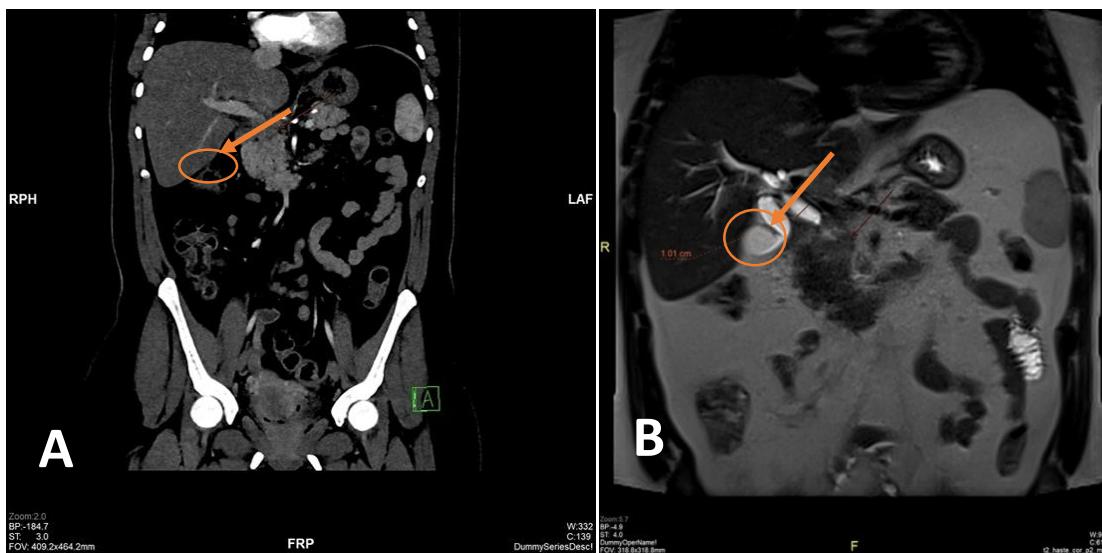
A) CT scan of the abdomen showing the ill-defined lesion and dilated CBD. B) MRCP of the abdomen showing ill-defined mass at the mid aspect of the CBD inseparable from the pancreatic head (arrows), resulting in biliary duct dilation (circle).
